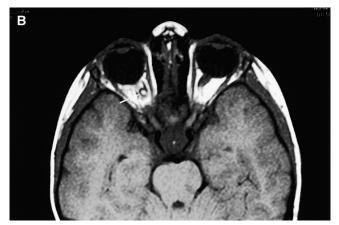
A 4-year-old girl with a right esotropia since birth. (A) Photograph of the right optic disc demonstrating the characteristic appearance reminiscent of the bloom of the *Ipomoea sp* from which the MGS appellation is borrowed. (B and C) T1-weighted (600/15/2) pre- (B) and post (C) contrast axial 3 mm images through the optic nerve. A small hyperintense signal focus is present (B, *white arrow*), situated centrally within the right optic nerve on multiplanar images (not shown). This focus produces a nonenhancing signal void on the fat-saturated post-contrast image (*white arrowhead*), consistent with fat within the nerve.
